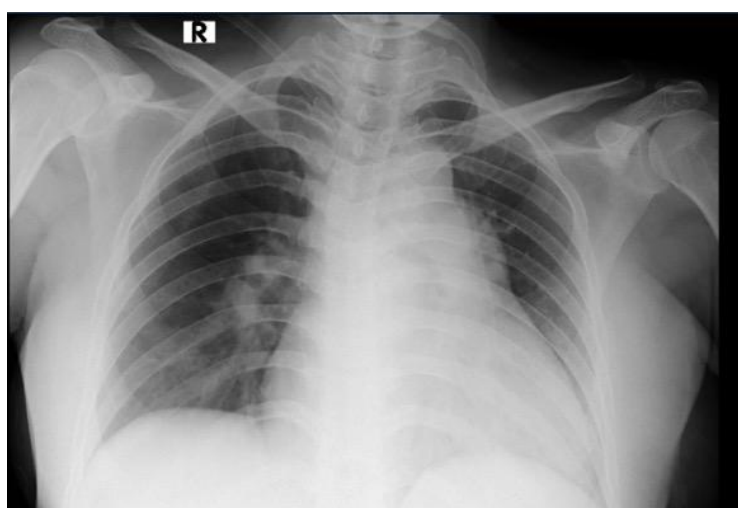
Preoperative posteroanterior chest radiograph demonstrating cardiomegaly with a cardiothoracic ratio of approximately 60% and clear lung fields, consistent with chronic right heart enlargement rather than acute pulmonary oedema.
